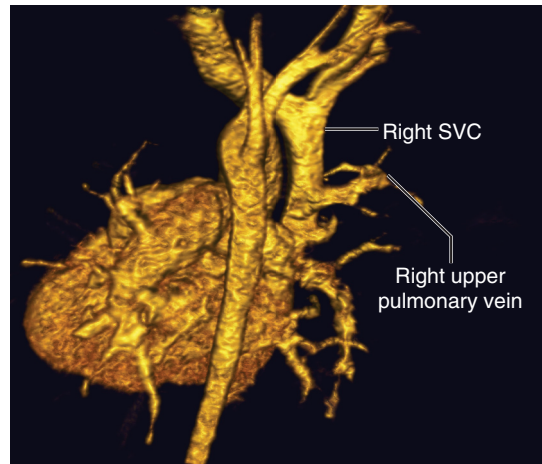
■ Three-dimensional cardiac magnetic resonance image of a heart (posterior view), showing right upper pulmonary veins anomalously entering the superior vena cava (SVC), cephalad to the atriocaval junction in a patient with superior sinus venosus atrial septal defect. (Courtesy David Parra, MD, Vanderbilt Children's Heart Institute.)
